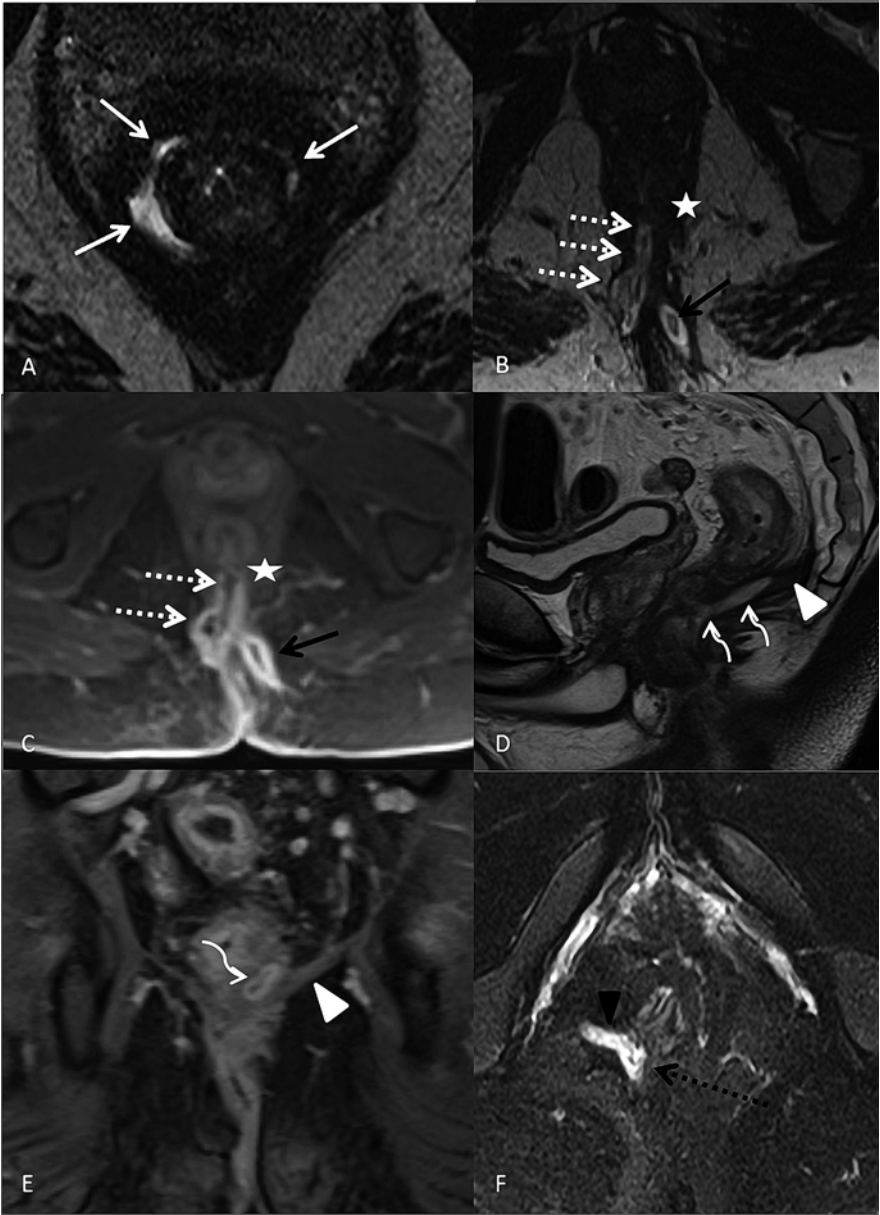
Axial T2-weighted MR image through the anal canal (a) shows an intersphincteric fistula (*white arrows*) tracking in the space between the internal and external anal sphincters. Axial T2-weighted (b) and axial T1 contrast-enhanced (c) MR images through the anal canal in a different patient show a transsphincteric fistula (*dashed white arrows*) which extends through the external anal sphincter (*white star*) to the ischioanal fossa. Sagittal T2-weighted (d) and coronal T1-weighted contrast-enhanced (e) MR images from a different patient with a supralevator fistula. On the sagittal image, the fistula (*curved white arrows*) is seen in the intersphincteric space extending cephalad, above the levator ani (*white arrowhead*). The coronal contrast-enhanced T1 image shows the tract (*curved arrow*) with peripheral enhancement extending above the levator (*white arrowhead*). Axial T2-weighted, fat-suppressed image from a different patient (f) shows a T2 hyperintense branching tract with intersphincteric (*dashed black arrow*) and transsphincteric (*black arrow head*) components
